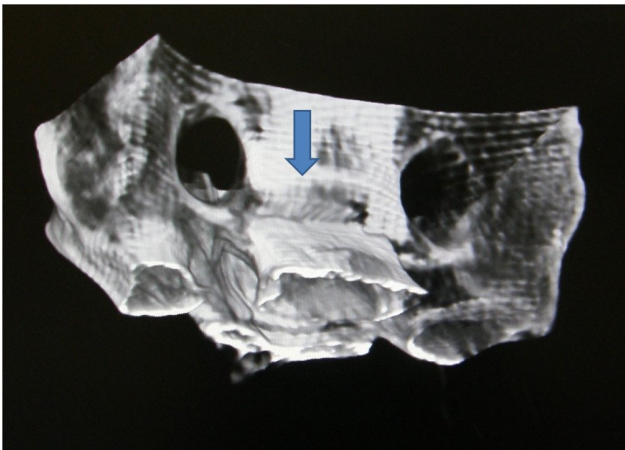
3D CT scan of the sacral bone of King Canute the Saint. The infraction on the anterior surface was a so-called hinge fracture, wherein the fractured area of the lamina compacta was still partially attached to its original bone.
